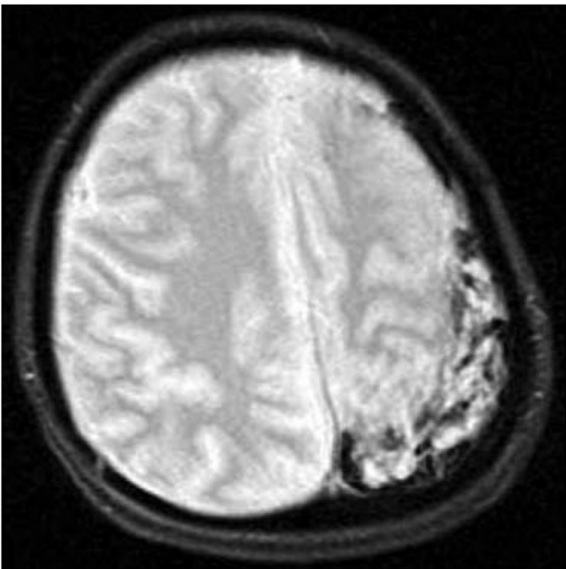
Magnetic resonance images, including T2* weighted images at the time of admission, revealed a left subdural mass consisting of multiple heterogenous calcifications.
